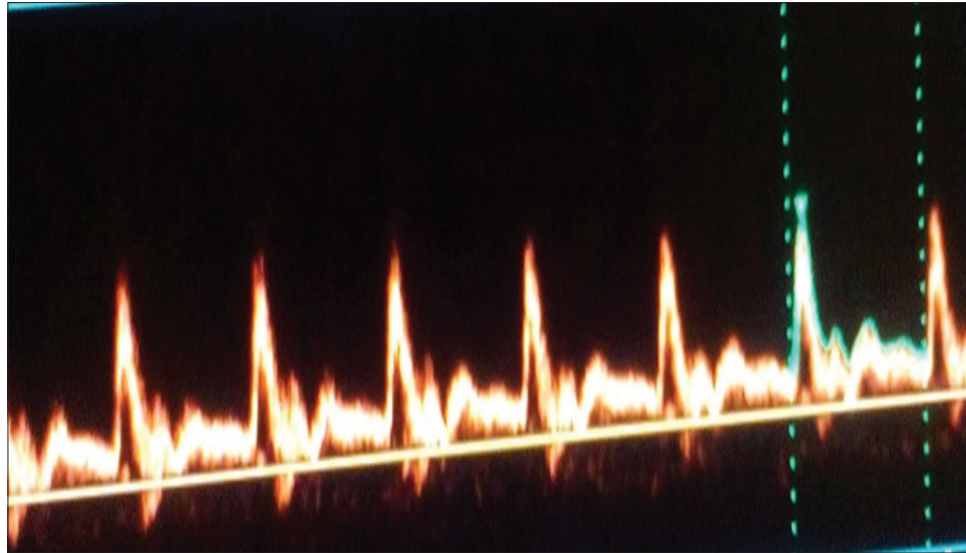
Doppler analysis of left common carotid arteries of an 80-year-old female known diabetic and hypertensive for 20 years having left side capsular small ischemic stroke resistive index = 0.78
